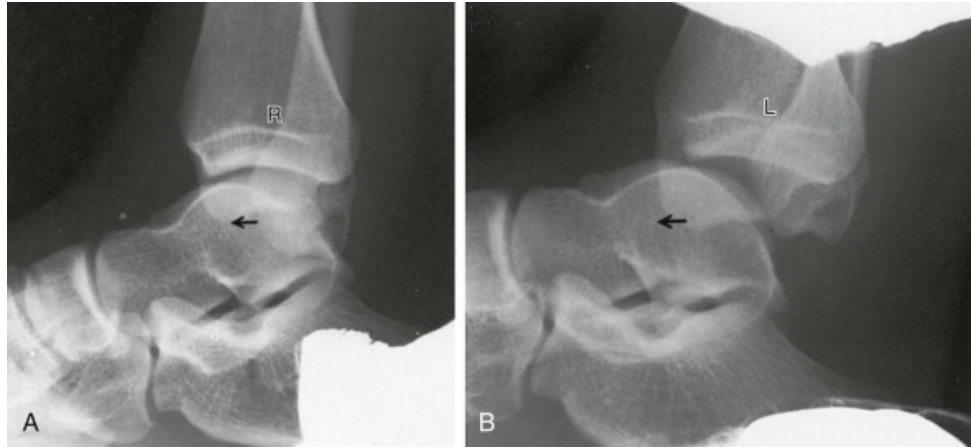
Anterior drawer test using stress radiograph showing anterior displacement of the talus (B) compared to the other normal side (A) (Coughlin et al., 2014).
